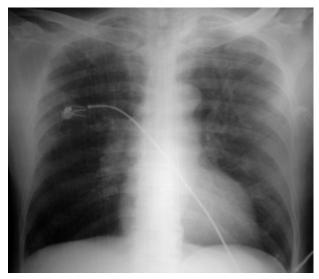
Chest radiograph of the patient with COPD presenting with acute LVF. For description, please see text.
